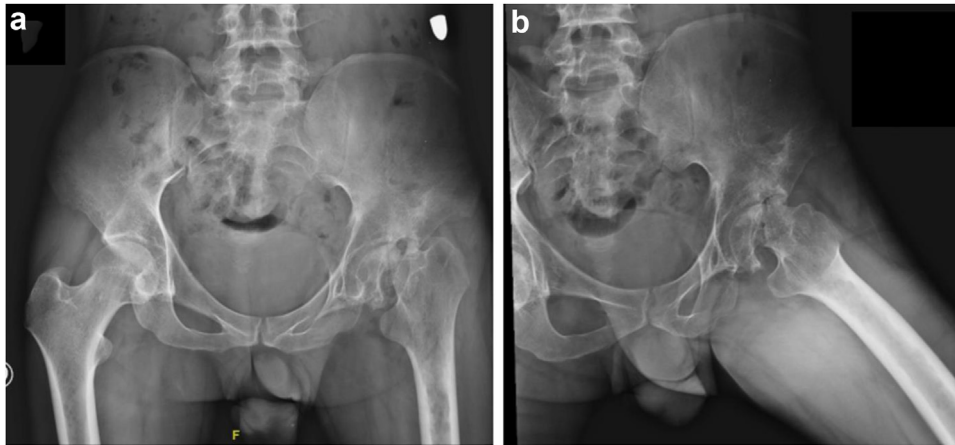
Preoperative pelvis anteroposterior (a) and left hip cross-table (b) radiographs two years after first ballistic surgery.
